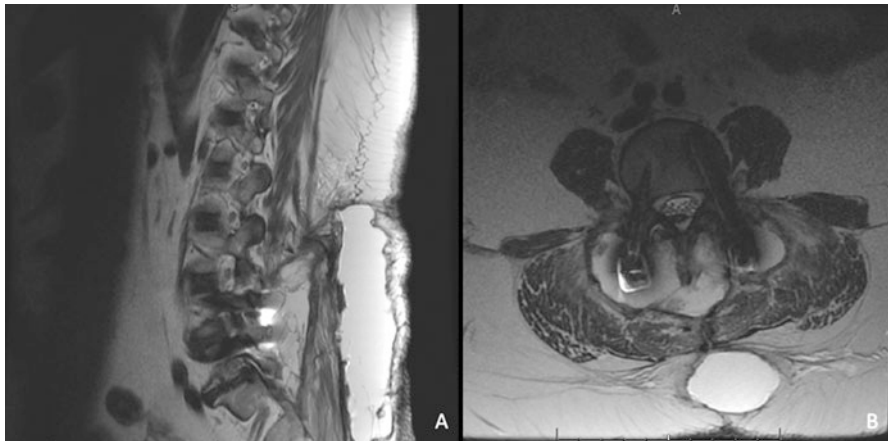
(a) Parasagittal T2-weighted MRI showing superficial and deep fluid collections. (b) The pedicle screw sign can be seen with fluid collections extending more than 5 mm outside the lateral edge of the head of the pedicle screw in the axial plane. This wound should be presumed infected unless proven otherwise
